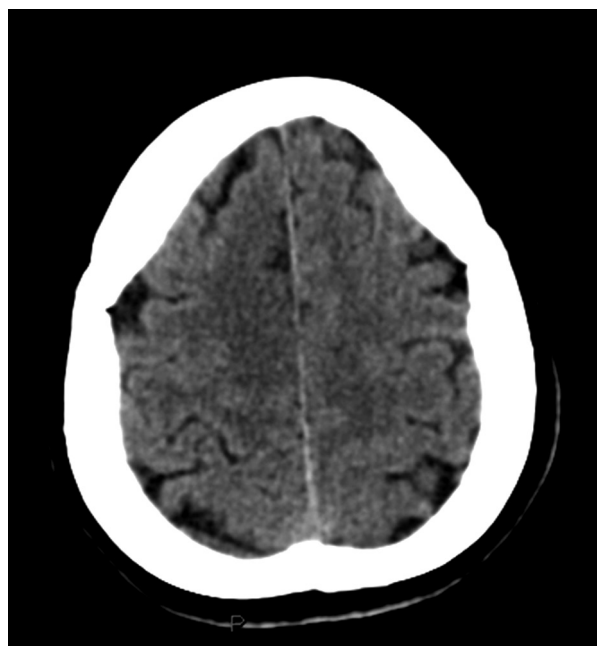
CT of the brain, fresh ischemia in the basin of the right anterior cerebral artery
